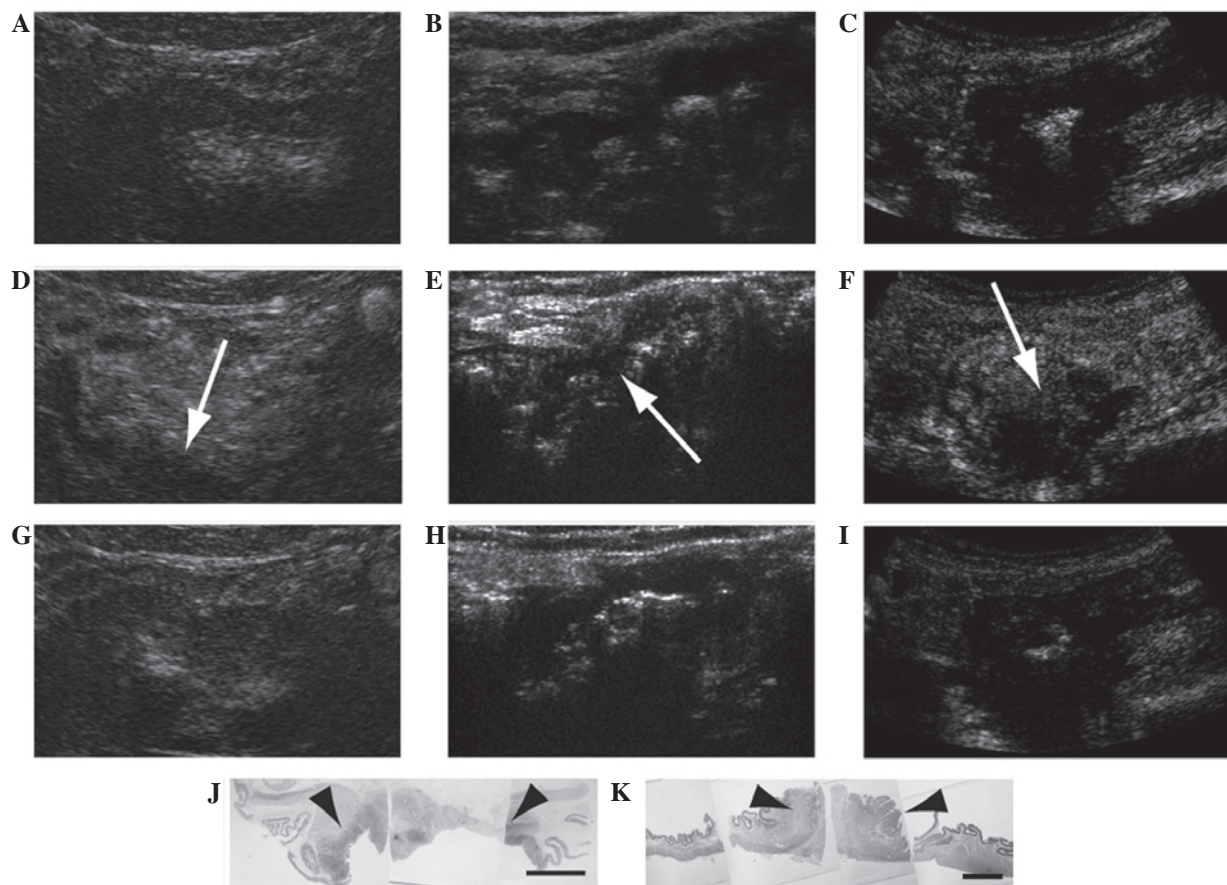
Contrast-enhanced ultrasonography of colorectal cancer. (A-C) Colonic wall showing thickening, irregular shape and low echo, and (D-F) 1 min after and (G-I) 10 min after administration of Sonazoid™. Patients (A, D, G) one, (B, E, H) two and (C, F, I) three showed the same enhancement trend. (B, E, H) The thickened wall was enhanced with Sonazoid™ 1 min after its administration. (D, E, F) Part of the thickened wall remained unenhanced (indicated by arrows). (D, F) Shapes of tumorous areas (indicated by arrowheads) resembled those of the unenhanced areas in patient (J) two and (K) three. Scale bar, 10 mm.
